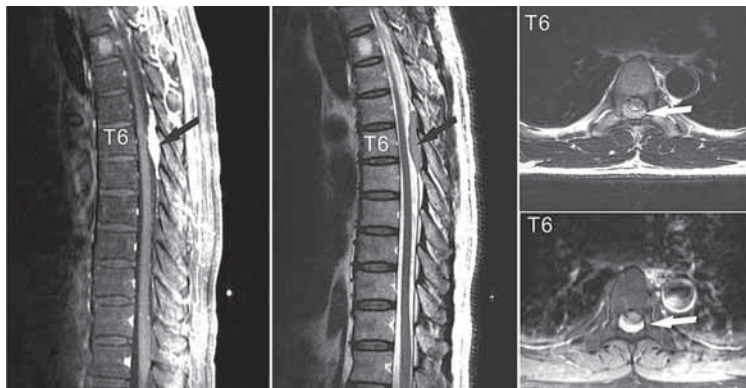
MRI of spine. *Left*: T1WI + Gd enhancement sagittal view: a strong enhancement fusiform lesion over T5-6 level. *Middle*: T2WI sagittal view. Black arrow indicates the extradural lesion. *Right upper*: T2 axial view. *Right lower*: T1+Gd axial view. White arrow indicates the lesion.
